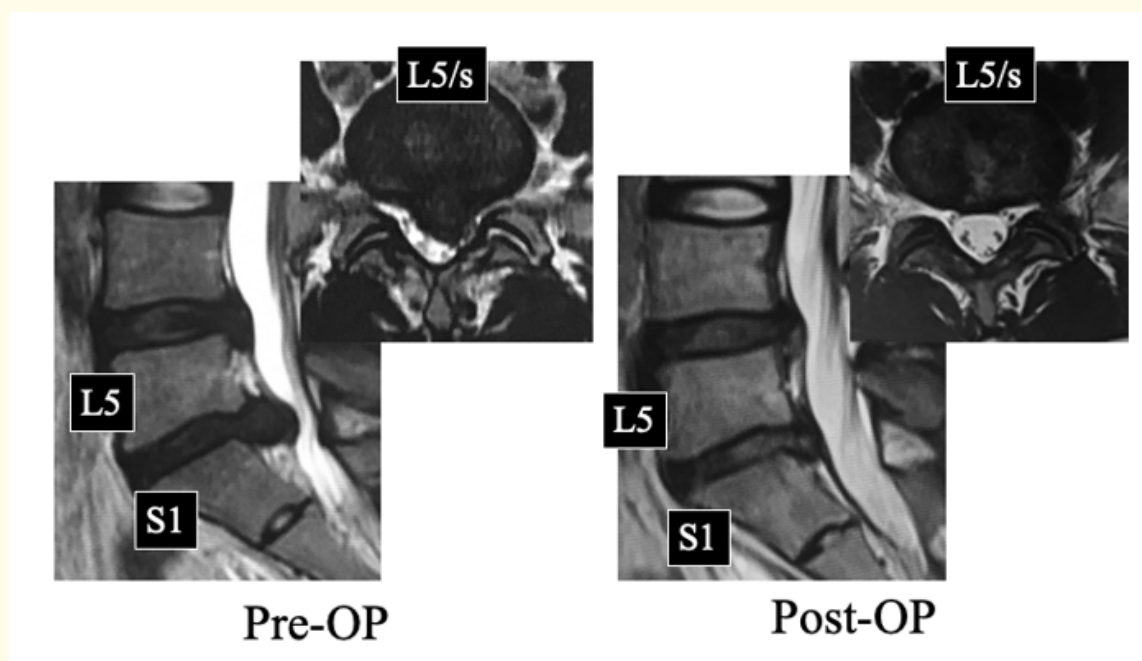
Magnetic resonance images obtained before and after transforaminal full-endoscopic spine surgery in a professional golfer. A herniated nucleus pulposus was able to be removed after foraminoplasty. Two months later, the patient returned to playing golf.
